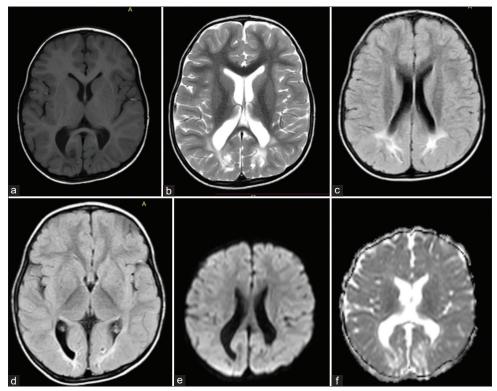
Birth Hypoxic ischemic insult. III-defined axial T2 and FLAIR (b-d) hyperintensity in subcortical and deep white matter of bilateral occipital and posterior parietal lobes, appearing hypointense on axial T1 (a), showing no restriction on DWI (e) and increased ADC (f) value, associated with white matter volume loss causing prominence of occipital horns of bilateral lateral ventricles
